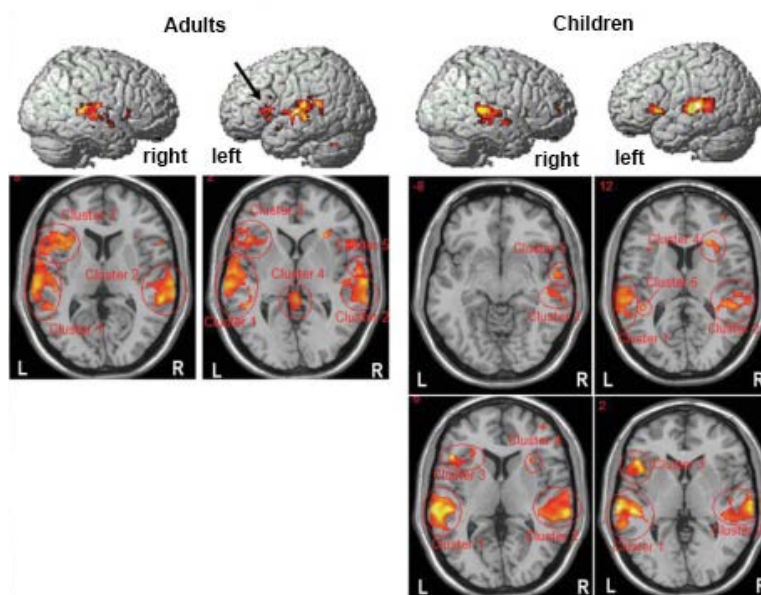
Clusters for the HPDT in adults (n=11) and in children (n=10) on selected axial T1-weighted images and the lateral view of the brain. Adults (left side): note BOLD responses in the STG (clusters 1 and 2) including the primary auditory cortex; in the IFG (cluster 3 and arrow, left lateral view) with Brodmann area 44 and branches extending to the insula. Children (right side): in the left hemisphere, the largest cluster present was located in the MTG, incorporating parts of the STG with the primary auditory cortex (cluster 1). The second cluster was found in the IFG and the left insula, activating parts of BA 44 and 45 (cluster 3). In the right hemisphere, note 2 clusters found in the STG (clusters 2 and 5).⁴
